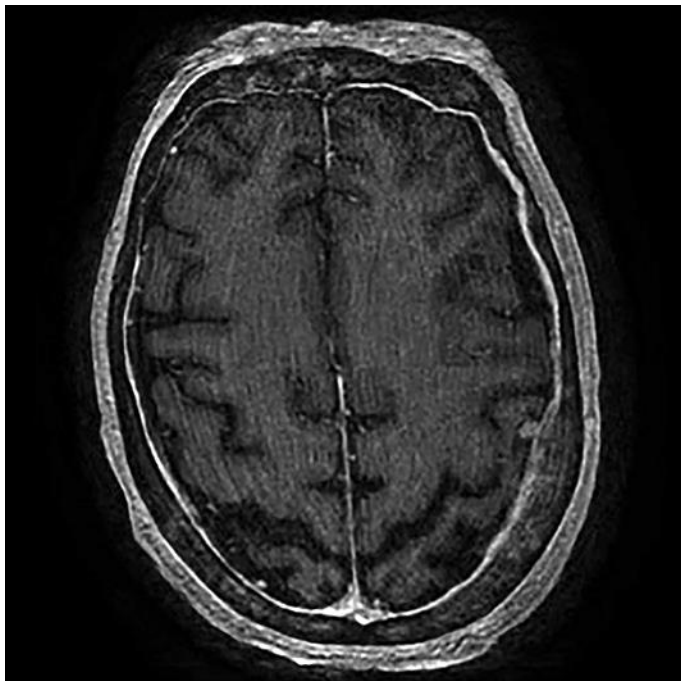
Diffuse meningeal enhancement on MRI of the brain – transverse view.
